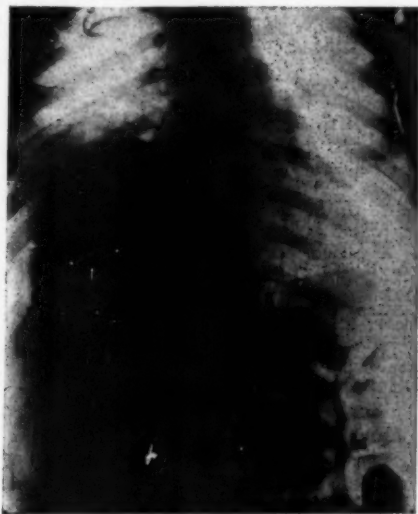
Roentgenogram made of the patient in the recumbent position, showing the marked herniation of the colon into the right pleural cavity.
